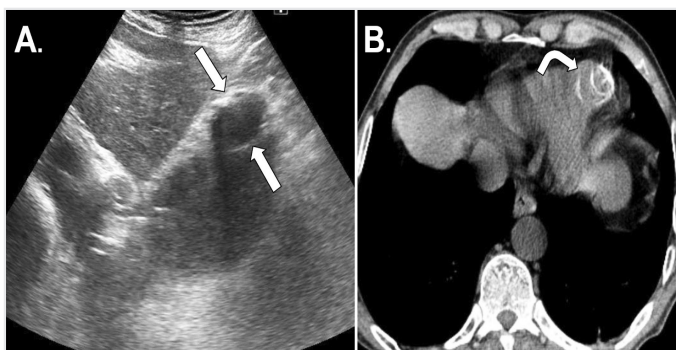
(Patient 22*) A 60-year-old male patient with Gharbi type 5 cyst of the left ventricular apex. The cyst is hypoechoic on TTE and has hyperechoic peripheral calcification (arrows, A). On the axial CT image, the cyst is hypodense with hyperdense peripheral calcification (curved arrow, B)
